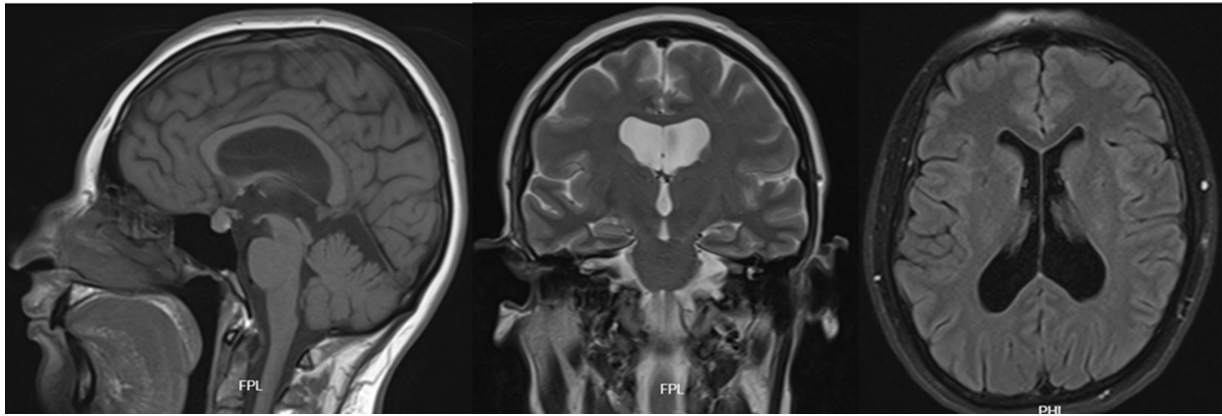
Postoperative MRI sagittal T1 sequence depicting a fenestrated Liliequist membrane after ETV, resulting in a substantial reduction in ventricular dilation. The presence of hypophyseal hyperplasia is consistent with the patient's pregnancy. The axial T2 FLAIR sequence displays no signs of active hydrocephalus, as evidenced by the absence of transependymal migration.
